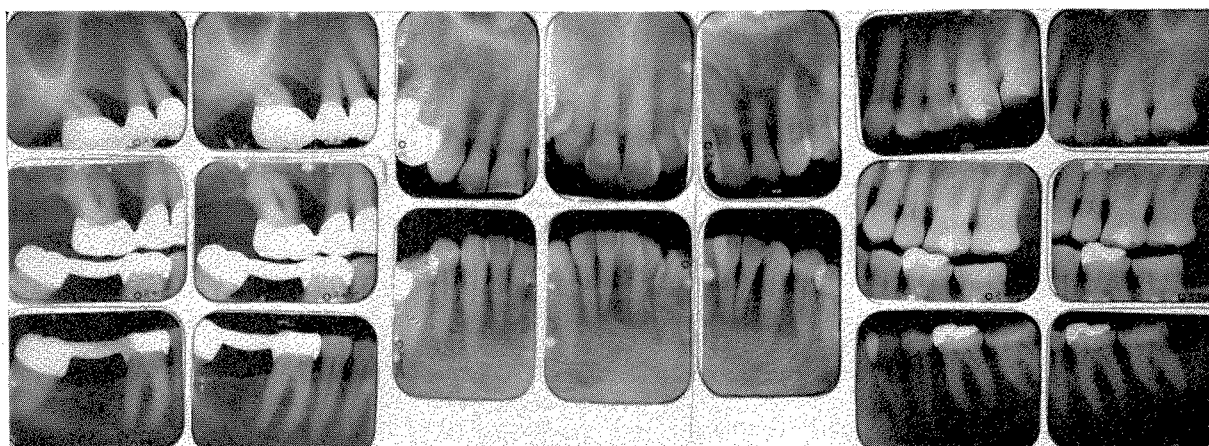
Roentgenograms taken in March, 1961. The health of the periodontal tissues had improved. No teeth had been lost since 1948.
